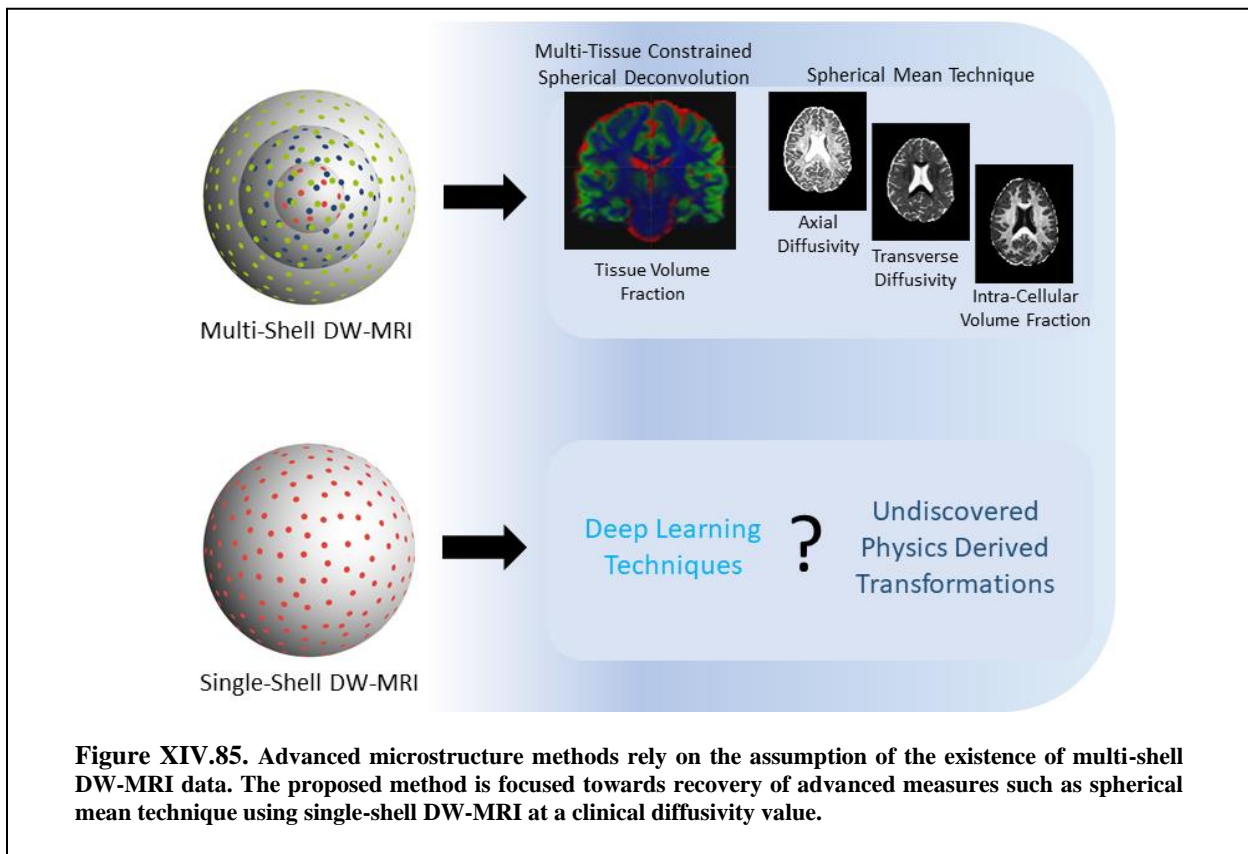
85. Advanced microstructure methods rely on the assumption of the existence of multi-shell DW-MRI data. The proposed method is focused towards recovery of advanced measures such as spherical mean technique using single-shell DW-MRI at a clinical diffusivity value.
